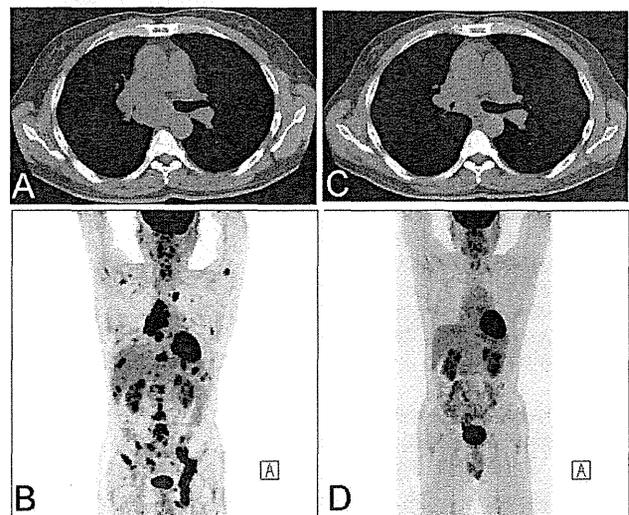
A, Chest computed tomography showed a narrowing of the right main bronchus due to massive lymphadenopathy. B, FDG-PET suggested multiple lymph node metastases and bone metastases. C, Six weeks after administration of the ALK inhibitor, the effect of the treatment was judged as partial response based on RECIST. D, Five months after administration of the ALK inhibitor, abnormal accumulation on FDG-PET had disappeared. FDG-PET, fluorodeoxyglucose positron emission tomography.
